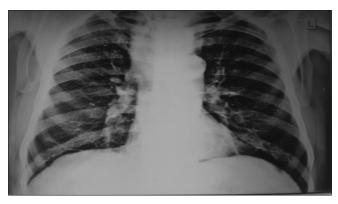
Chest X-ray with deviation of the mediastinum to the right suggesting left superior mediastinal mass
